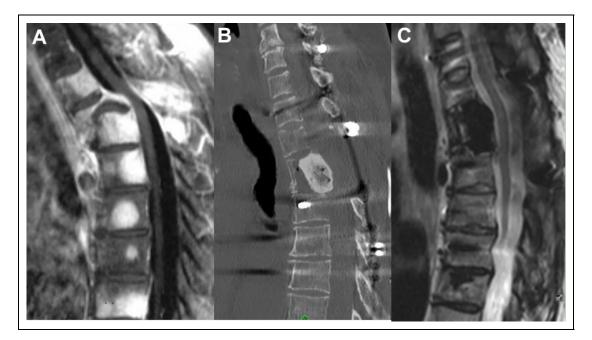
A, Post contrast T1 W image showing T3 fracture dislocation from breast metastasis. B, Post-operative CT image showing dorsal cage migration impinging the cord. This is due to incomplete disc preparation at the time of surgery. C, Post-operative T2 W MRI image following revision surgery showing cement retrieval and re-vertebrectomy and reconstruction with PMMA.
